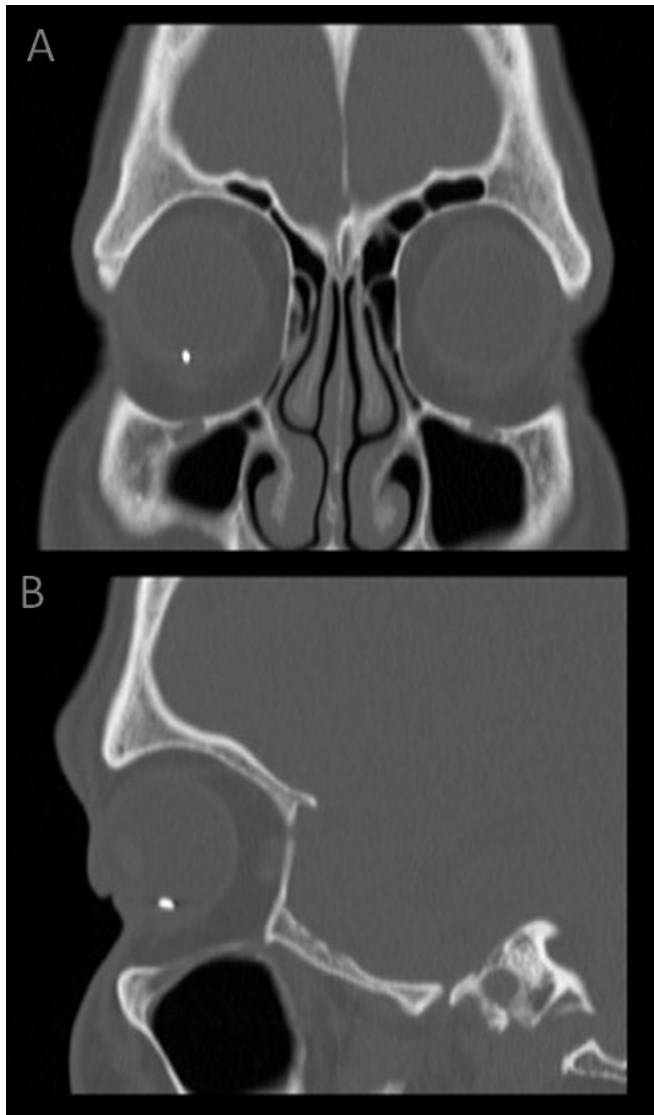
An orbital noncontrast CT of the right eye. A 3 mm hyperdense lesion localised inferiorly and compatible with a metallic foreign body was seen on coronal plane (A) and sagittal plane (B).
